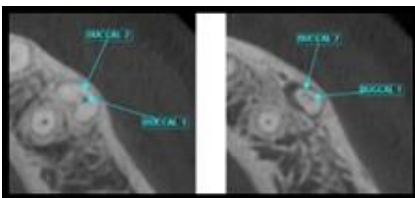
Axial view of CBCT of location of 2 buccal canals
